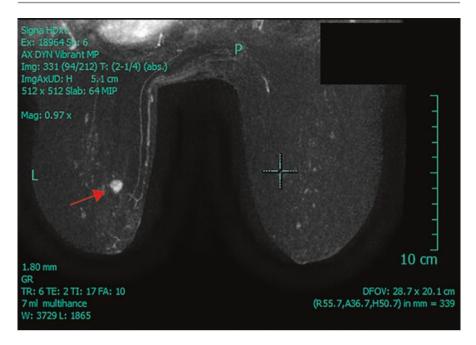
Pre-cryoablation breast MRI demonstrating a unifocal tumor in the left breast (*arrow*) (Courtesy of Dr. Rosa Hwang)
